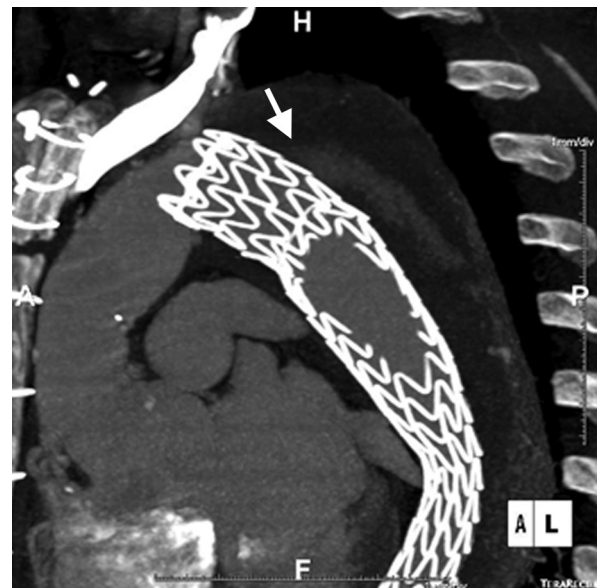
Sagittal computed tomography image showing the endoleak within the false lumen of the descending aorta (*arrow*). The image was acquired before the endoleak repair.
